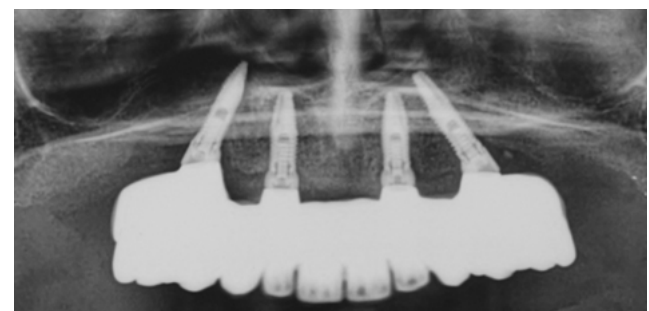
Final orthopantomography.
